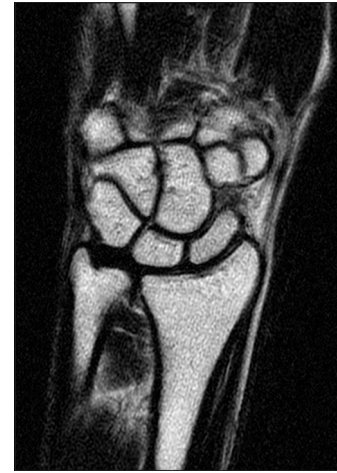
MRI Cor T2 FSE of right wrist joint
